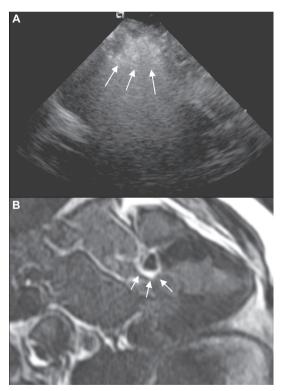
Triangular shaped ablated area visualized by intracardiac echocardiography during PTSMA (panel A) and corresponding infarct area visualized by MRI long axis (panel B).
